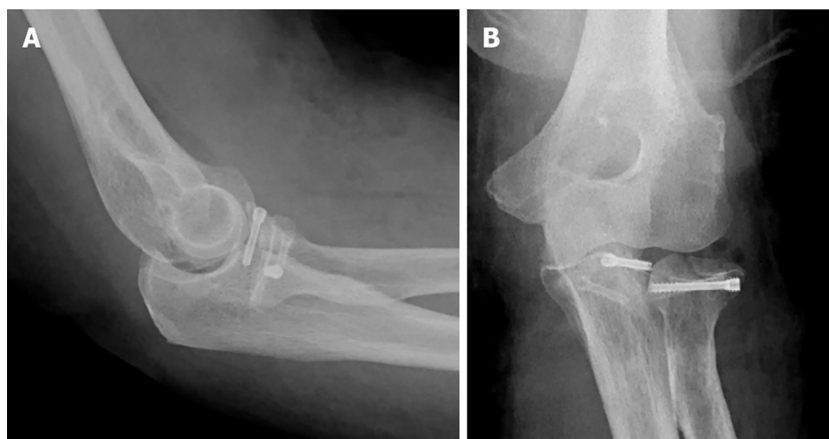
Immediate post-operative radiographs. A and B: Anterior – posterior (A) and lateral (B) views.
